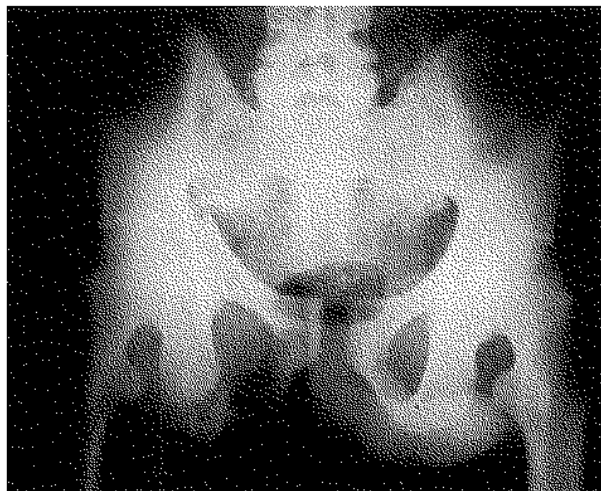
Initial radiograph: distinct downward dislocation of the sacrum.
